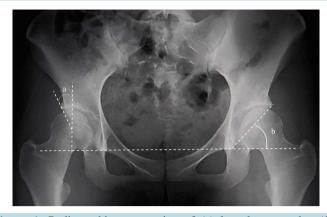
Radiographic presentation of (a) lateral center-edge (CE) angle and (b) sharp angle on AP view.
